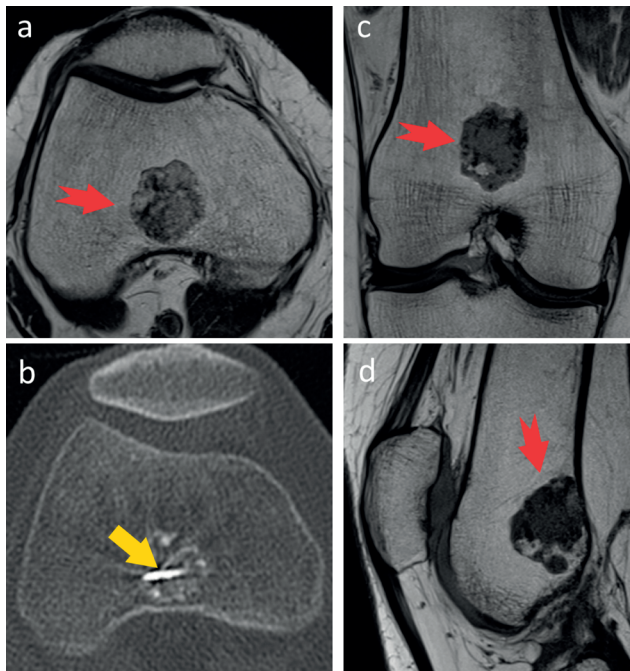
Panels a, b, and d show preoperative magnetic resonance images in different planes to evaluate an atypical cartilaginous tumour located in the metaphysis of the distal femur, with the tumour being indicated by the red notched arrow. c shows an intraoperative computed tomography image demonstrating the final location of the tip of the radiofrequency ablation electrode.
